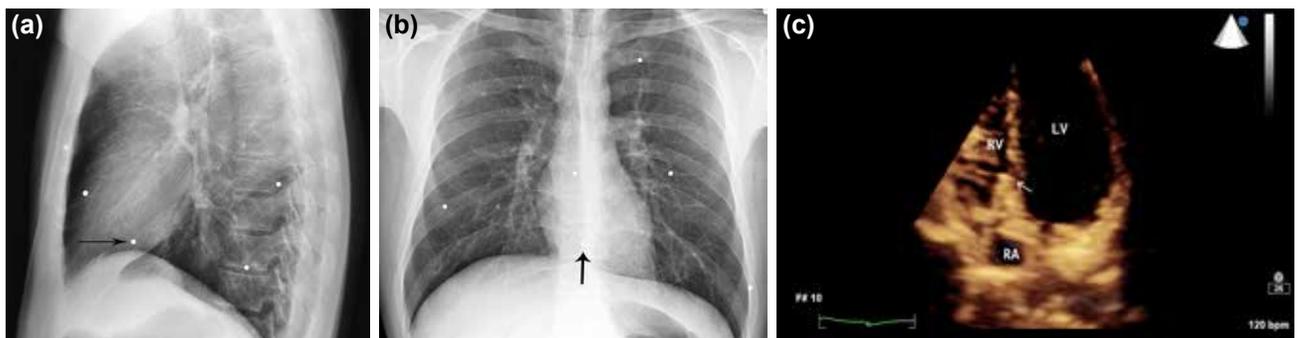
(a, b) Posteroanterior and lateral chest x-rays revealing the pellet (black arrows) in the silhouette of the heart, 6 weeks after discharge. (c) Echocardiograms at 6 months after discharge showing the pellet (white arrow) within the interventricular septum.
